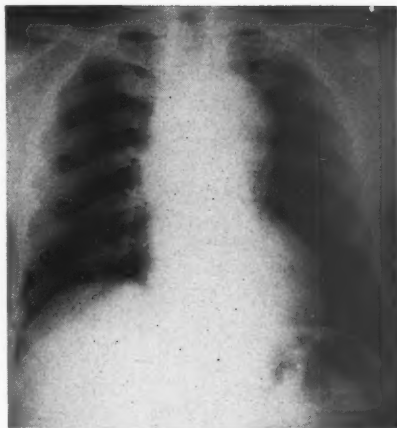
Roentgenogram of chest of a man aged 39 years who died 11 days after onset of acute illness ushered in by severe interscapular pain. The blood pressure was 250/190. Convulsions and abdominal pain characterized the latter part of the illness. Death was sudden. At postmortem examination the intimal tear was found just distal to the ligamentum arteriosum and there was massive hemothorax on the left.
